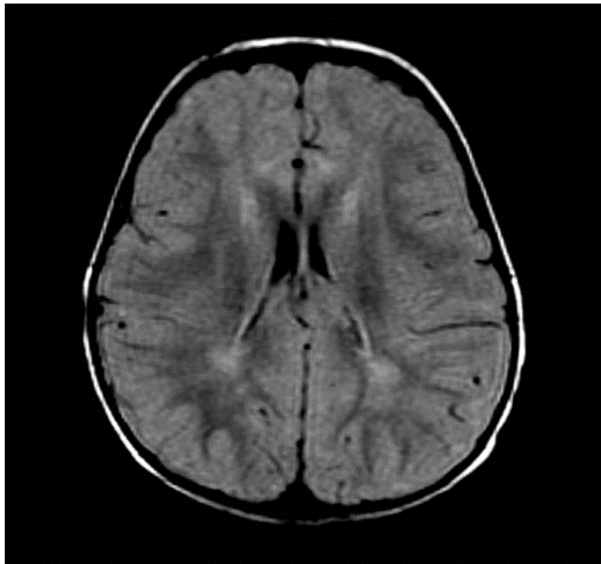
MRI scans. hypoplasia of the corpus callosum; dilated lateral ventricles (external hydrocephalus)
